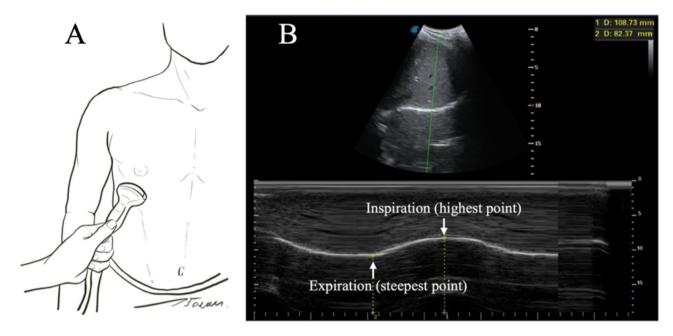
(A) Position the M-mode ultrasound transducer (B) Ultrasound images were obtained over this area.
